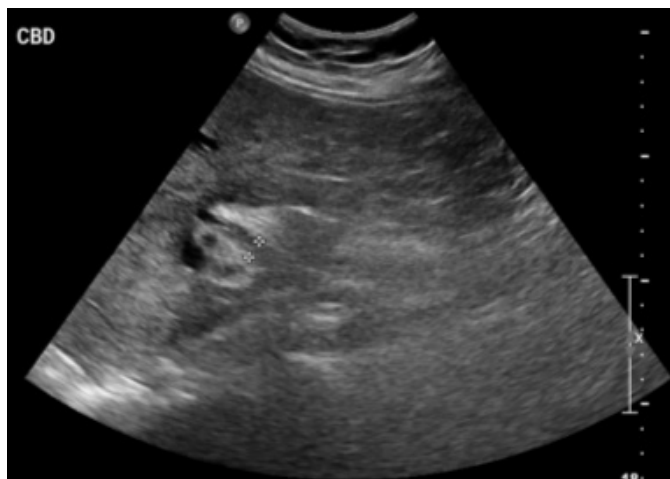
Ultrasound examination of the abdomen shows a borderline dilated common bile duct measuring 7.6 mm (Case 1).
